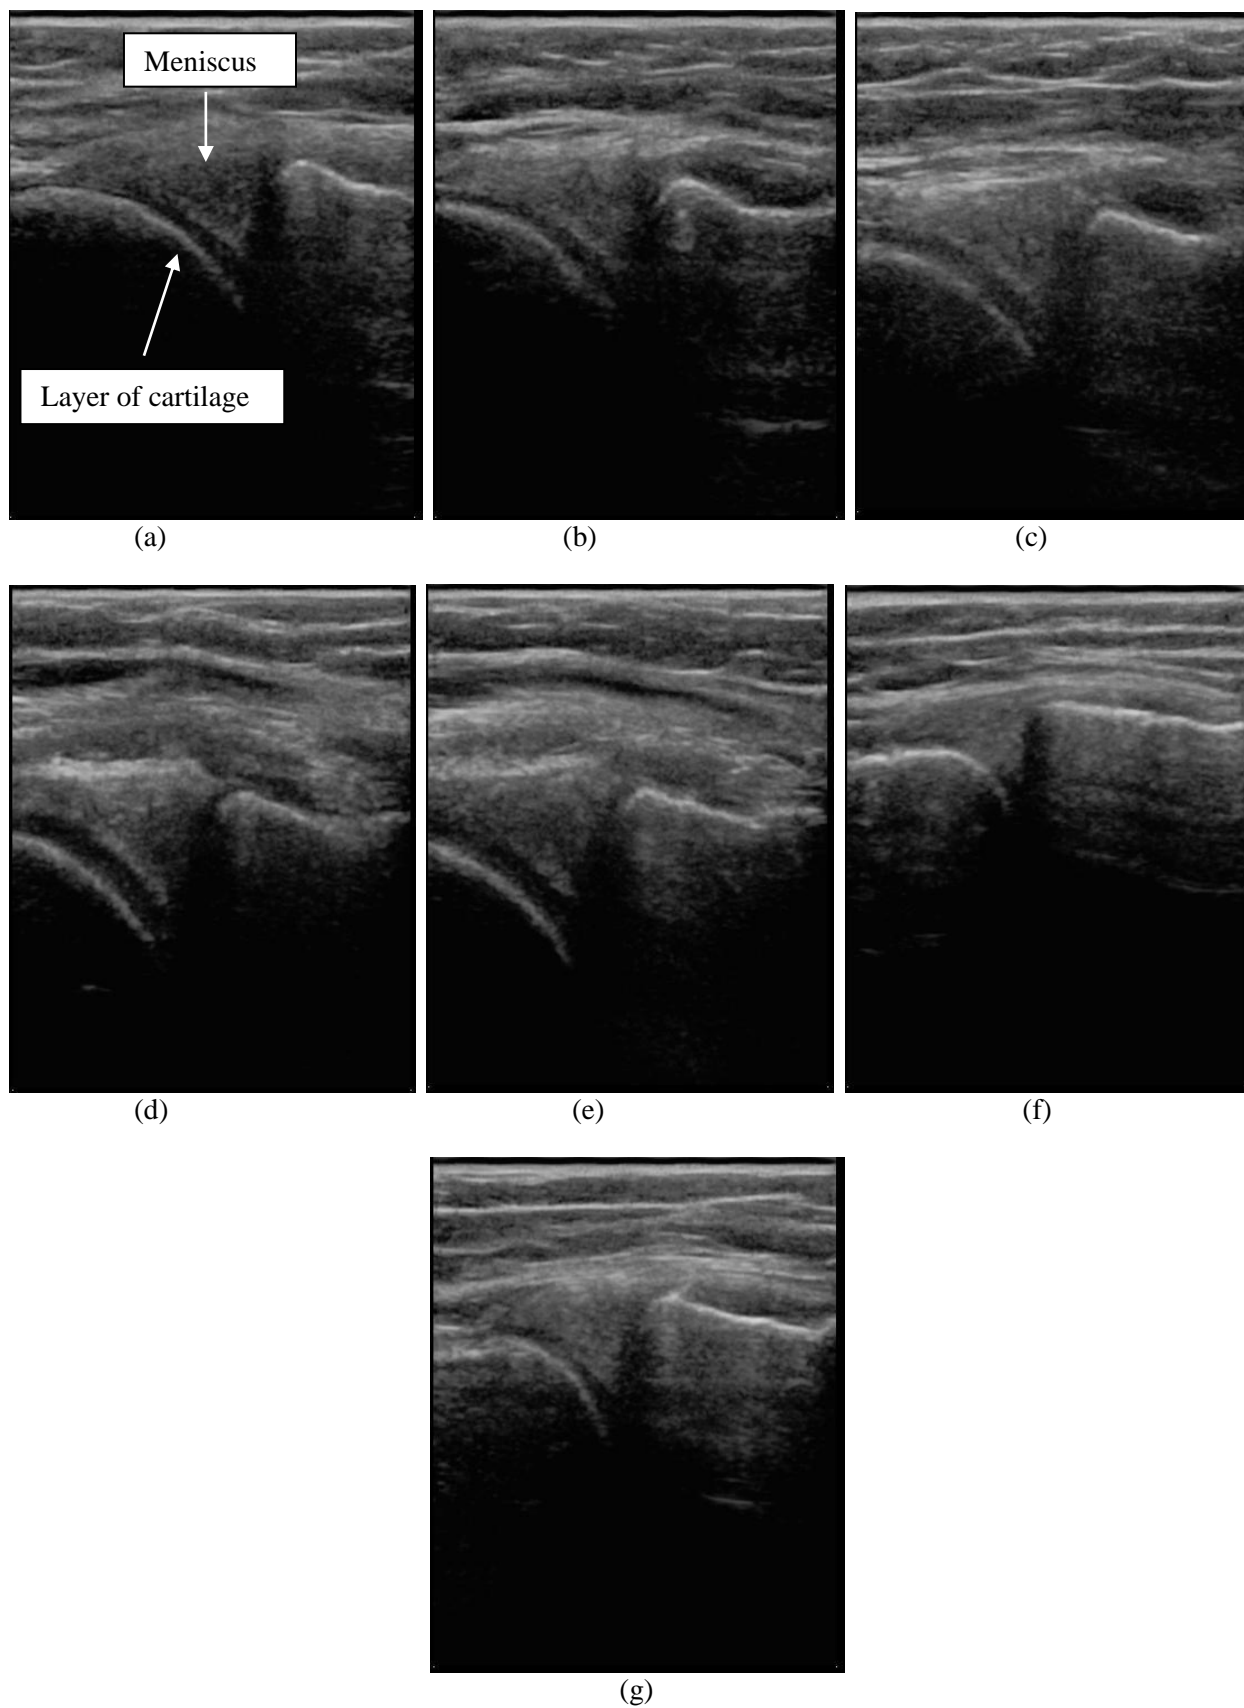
(a-g) is ultrasound image of knee joint Meniscus collected from UMMC (Healthy subjects)
